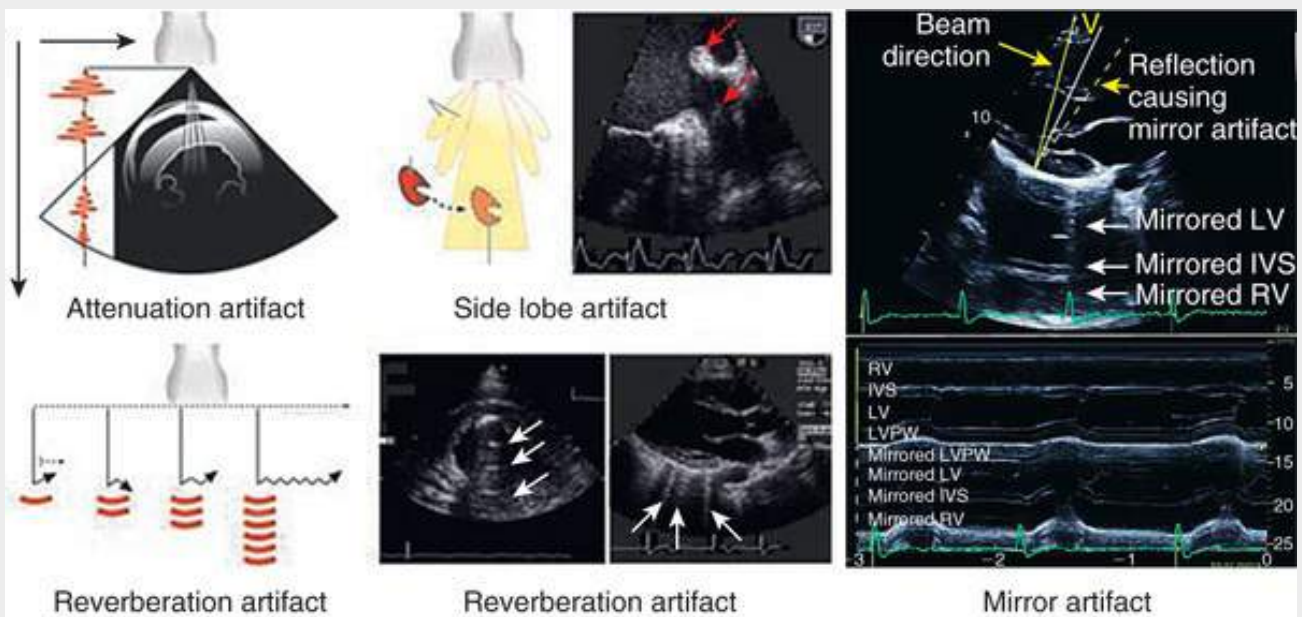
Common imaging artifacts seen in echocardiography. Attenuation artifacts, caused by diminution in ultrasound beam intensity with increasing depth, resulting in fading and dropout (upper left). Side lobe artifacts occur when structures in the path of the side lobe beams are erroneously mapped into the image (upper middle). Reverberation artifacts are common (lower left and middle panels). They may be large, as in the case of reflections from the inflow tube of an LVAD (three parallel *arrows*, below center), or appear as fine comet-tail or “ring-down” artifacts because of multiple reverberations that invariably occur at the highly specular epicardial-pleural interface (lower right). Right panels, Mirror artifact, caused by reflection between tissue interfaces and the transducer.
